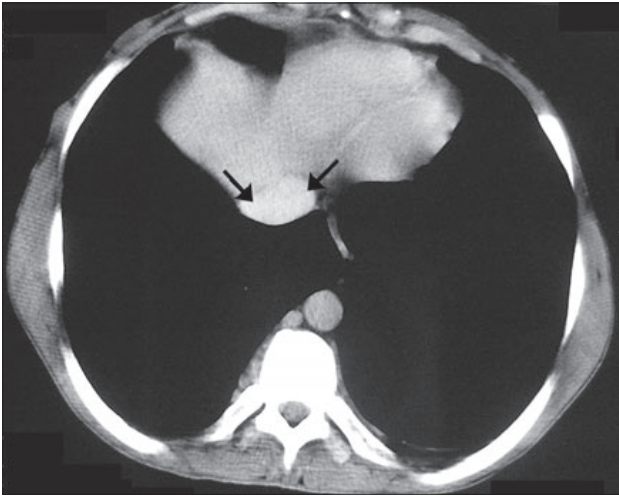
Abdominal computed tomography scan. Normal caliber suprahepatic segment of IVC.
